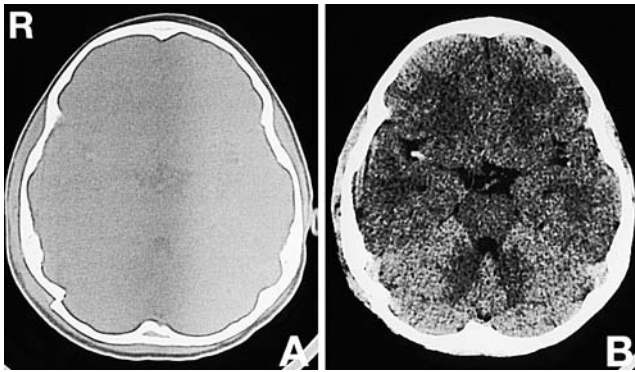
(A) Initial bone window computed tomography (CT) scan showing displacement of the fractured right occipital bone. (B) CT scan of the brain taken 5 hours later showing a small high-density component at the horizontal portion of the right middle cerebral artery but without intracerebral lesions.
